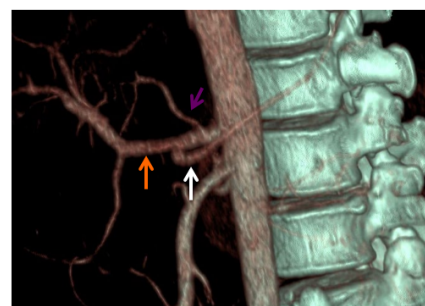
3D Reconstructed, VR oblique sagittal image showing normal non-classic pattern of type I CT with its three branches SA (White arrow), LGA (Purple arrow) and CHA (Orange arrow).
